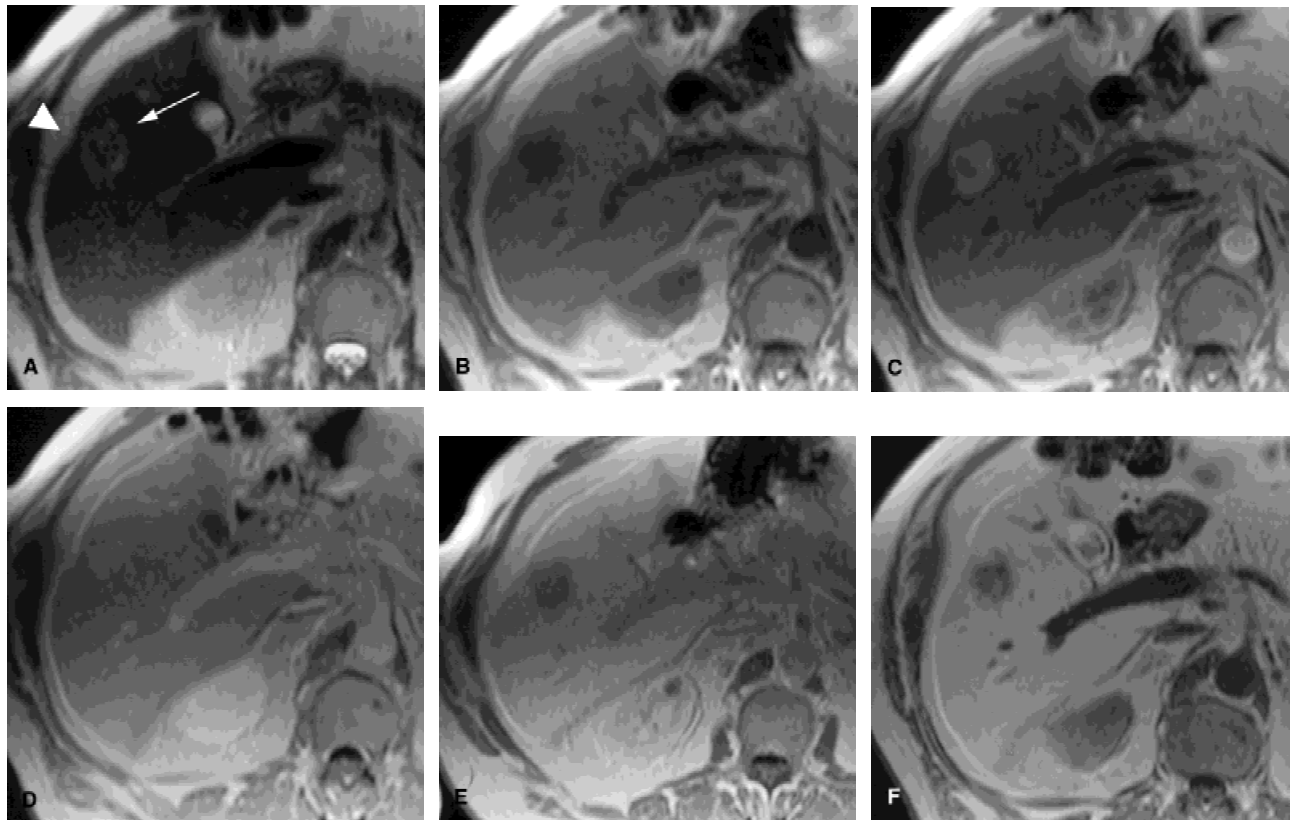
Hypervascular peripheral cholangiocarcinoma in a 66-year-old man. a: HASTE transverse T2-weighted image shows a small isointense lesion with hyperintense margins in the right lobe of the liver (arrow) and capsular retraction (arrowhead). b: GRE transverse T1 precontrast image. The lesion is homogeneously hypointense to the surrounding liver parenchyma. c: During the arterial phase of dynamic imaging with bolus administration of Gd-BOPTA (GRE transverse T1-weighted), the lesion is hyperintense. d: In the portal venous phase, the lesion shows a persistent enhancement. e: GRE transverse T1-weighted images obtained 2 hours after administration of Gd-BOPTA. Homogeneous enhancement of the liver is evident, and the lesion is hypointense with slight accumulation of contrast media (CM) in the desmoplastic center. f: GRE transverse T1-weighted images obtained 1 hour after administration of Mn-DPDP. The lesion is hypointense with slight accumulation of CM in the desmoplastic area.
